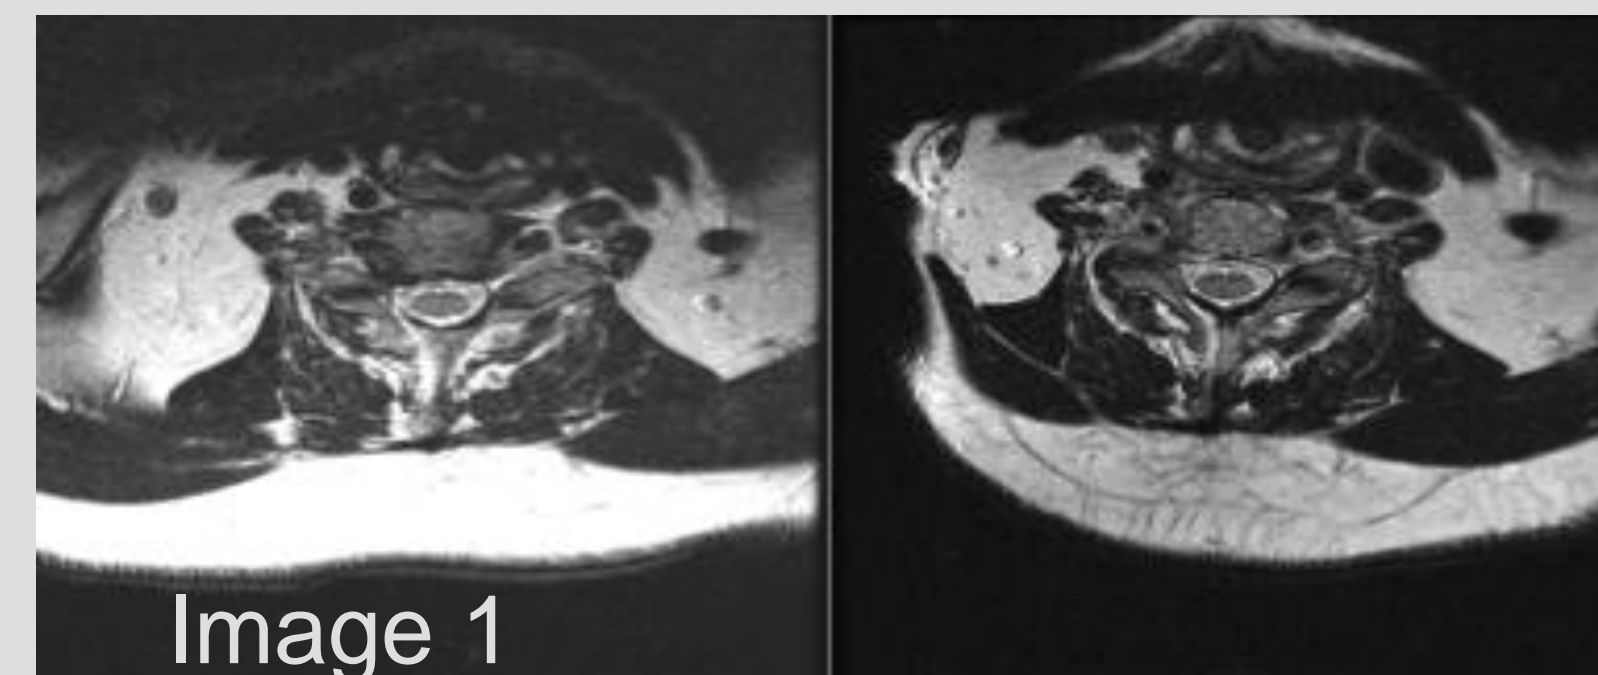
Left figure shows pre-operative MRI in a patient with right sided foraminal stenosis at C5/6. Right figure shows immediate post-operative MRI of same patient. Note the residual in buckling of the PLL however there has been complete removal of the herniated disc
